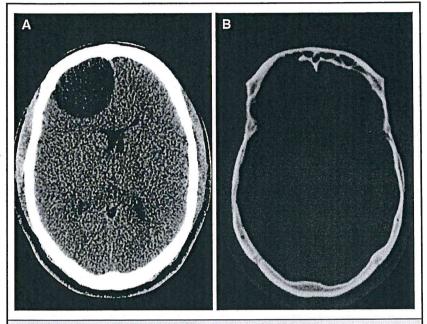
Adult male with chronic sinusitis and headaches. Right frontal sinus mucocele. A, Axial noncontrast CT shows a well-circumscribed extra-axial right frontal mass that is homogeneously mucoid density.
